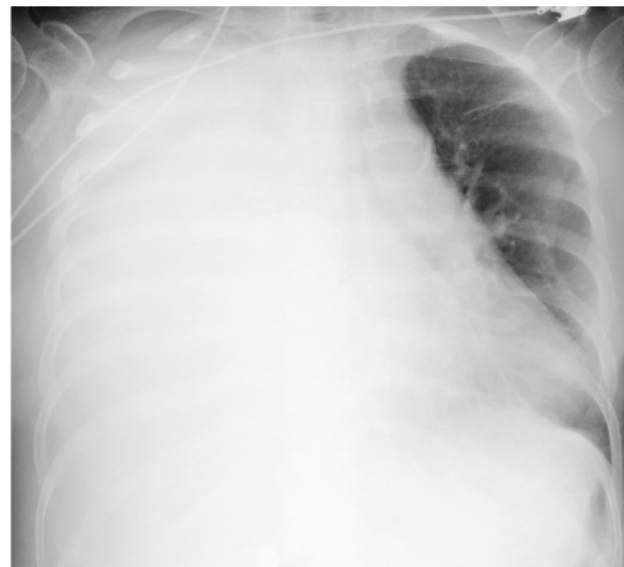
Chest radiography showing a massive right-sided pleural effusion.
